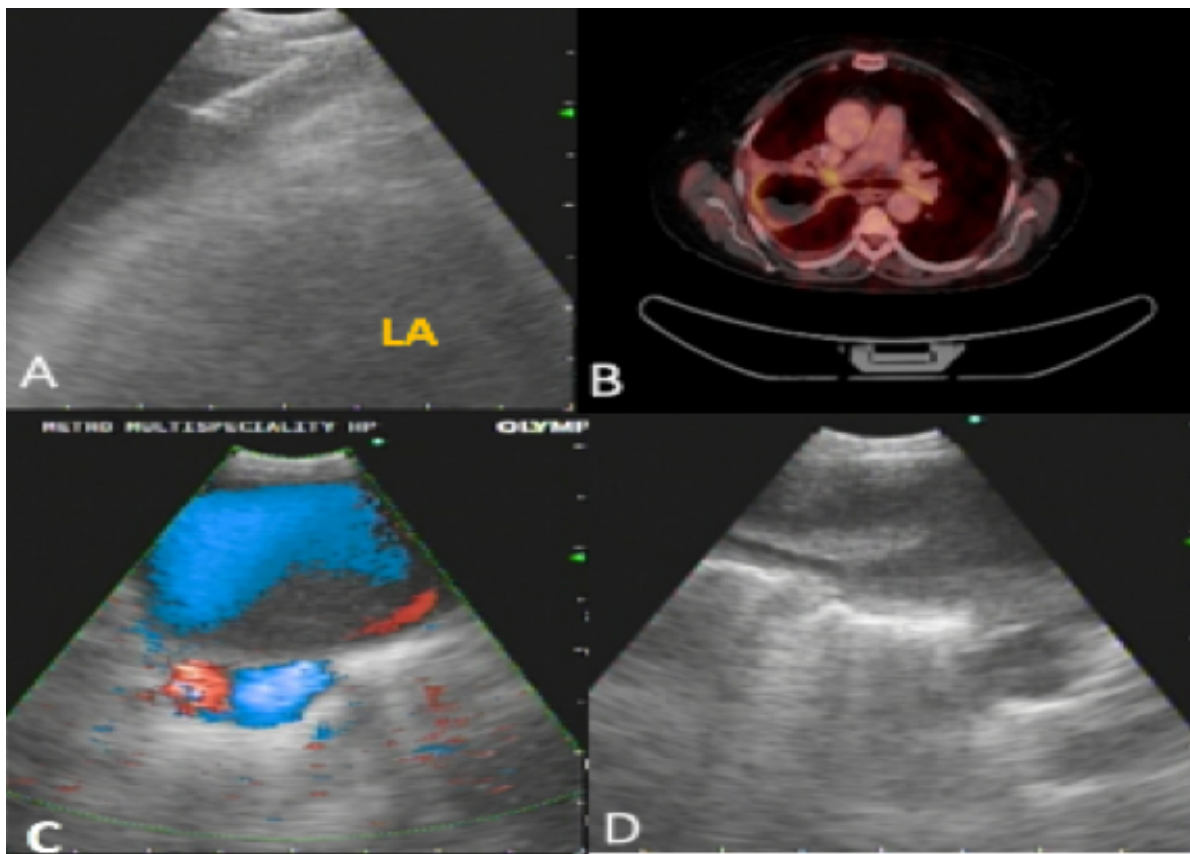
A) EBUS image of pericardial effusion seen above left atrium (LA) with EBUS-TBNA needle in-situ. B) PET-CT image showing PET avid thick walled cavity abutting the right main bronchus. C) EBUS doppler image showing inhomogenous opacity in pulmonary artery suggestive of thrombus & D) its partial resolution after thrombolysis.
